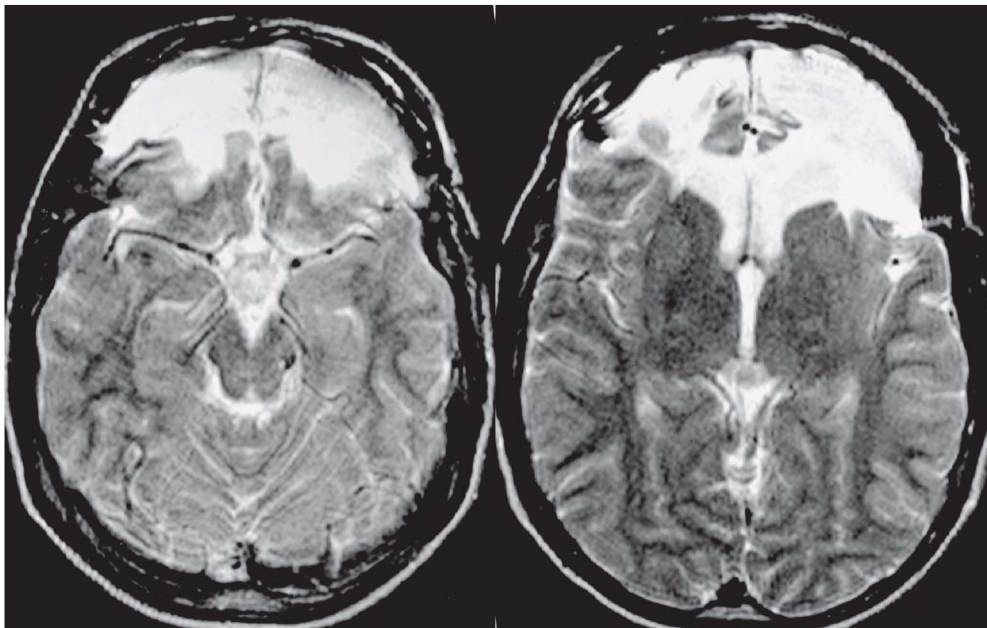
Brain magnetic resonance imaging (MRI) scans showing the focal prefrontal cortex lesions of a 9-year-old female (A) and 16-year-old male (B) who both suffered traumatic damage from falls early in life. Note the asymmetric right prefrontal lesion and surrounding tissue volume loss in A and the extensive bilateral lesion in B. Both patients showed significant developmental self-regulatory and executive deficits.
